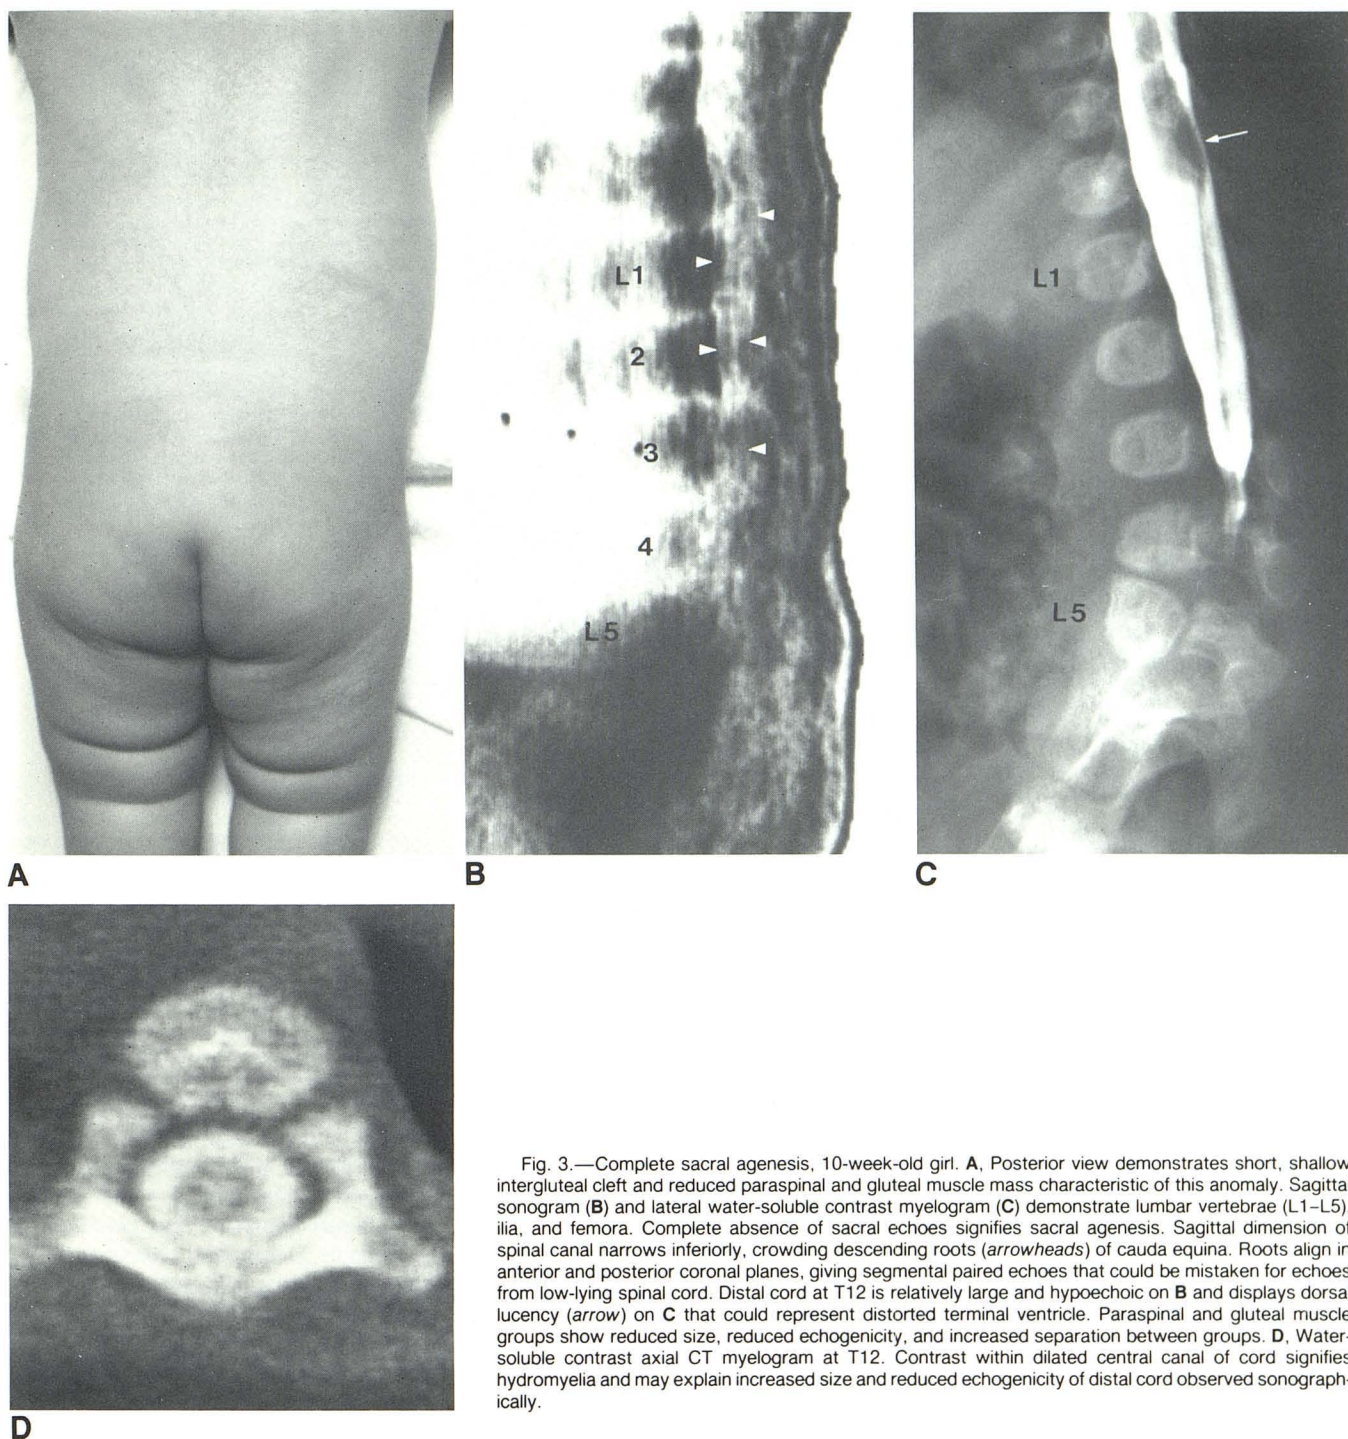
Complete sacral agenesis, 10-week-old girl. A, Posterior view demonstrates short, shallow intergluteal cleft and reduced paraspinal and gluteal muscle mass characteristic of this anomaly. Sagittal sonogram (B) and lateral water-soluble contrast myelogram (C) demonstrate lumbar vertebrae (L1–L5), ilia, and femora. Complete absence of sacral echoes signifies sacral agenesis. Sagittal dimension of spinal canal narrows inferiorly, crowding descending roots (*arrowheads*) of cauda equina. Roots align in anterior and posterior coronal planes, giving segmental paired echoes that could be mistaken for echoes from low-lying spinal cord. Distal cord at T12 is relatively large and hypoechoic on B and displays dorsal lucency (*arrow*) on C that could represent distorted terminal ventricle. Paraspinal and gluteal muscle groups show reduced size, reduced echogenicity, and increased separation between groups. D, Water-soluble contrast axial CT myelogram at T12. Contrast within dilated central canal of cord signifies hydromyelia and may explain increased size and reduced echogenicity of distal cord observed sonographically.
